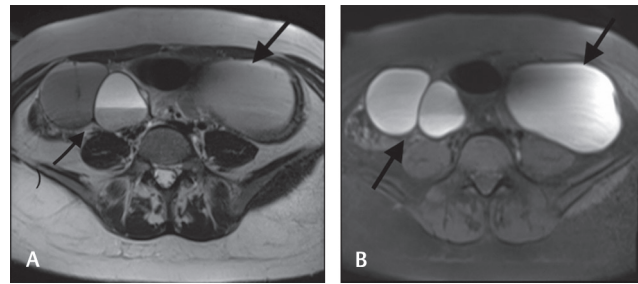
(A, B) T2W (A) and FS T1W (B) axial images showing bilateral endometriomas with T2 shading (arrow). FS, fat-suppressed; T1W, T1-weighted; T2W, T2-weighted.
